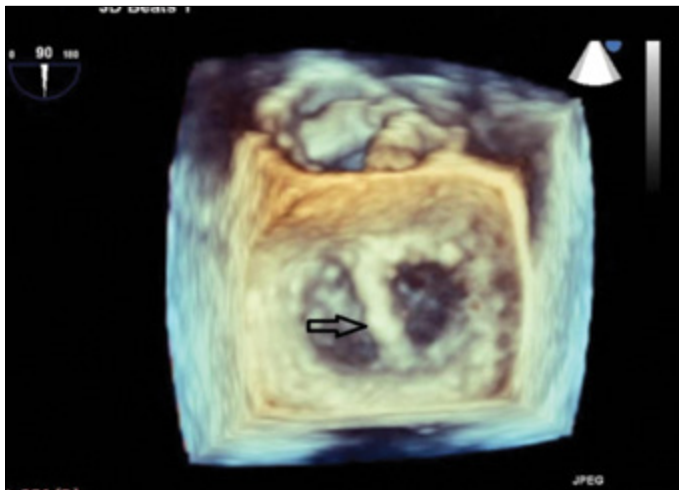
Three-dimensional transesophageal echocardiography demonstrates double orifice sign due to the dislocation of the mitral annuloplasty ring
